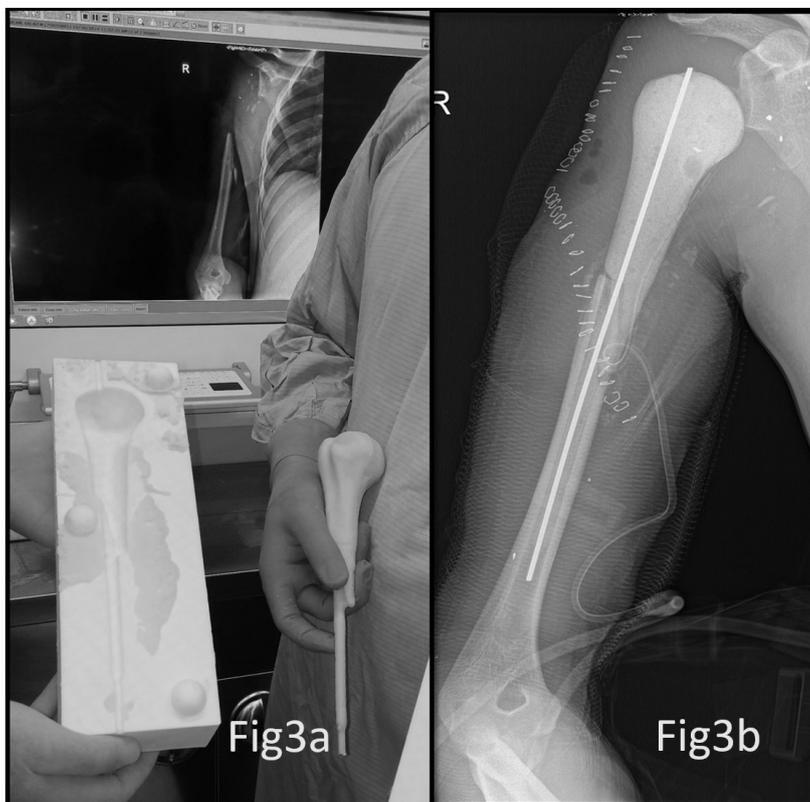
Photograph showing the resulting antibiotic cement spacer (foreground) and the injured right humerus x-ray (background).
